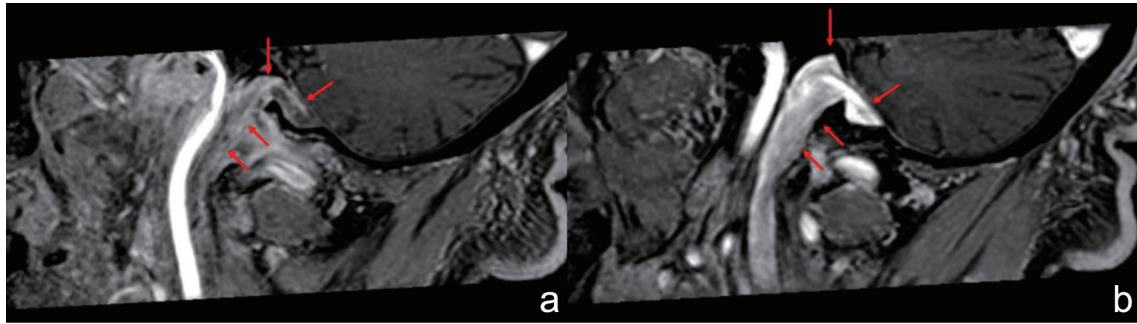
Magnetic resonance imaging (MRI) sagittal T1w image after gadolinium administration. (a) Thrombosis of sigmoid sinus and internal jugular vein (red arrows). (b) Right normal side, demonstrating normal appearance of sigmoid sinus and internal jugular vein (red arrows).
